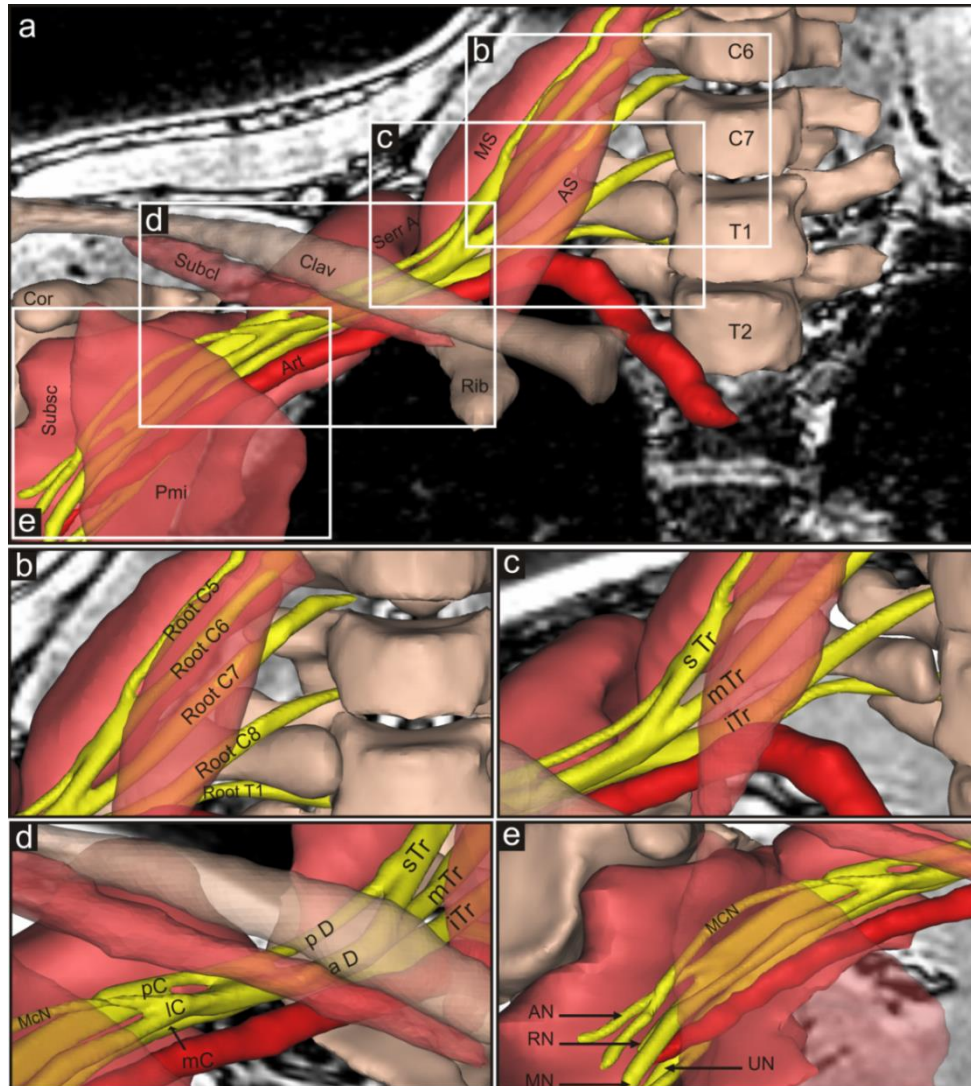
MRI-based 3D reconstructions of the brachial plexus and surrounding structures of a healthy volunteer (AS, anterior scalene muscle; MS, middle scalene muscle; Serr A, serratus anterior muscle; Subcl, subclavian muscle; Pmi, minor pectoral muscle; Subsc, subscapular muscle; clav, clavicle; cor, coracoid process; Art, axillary artery) .
